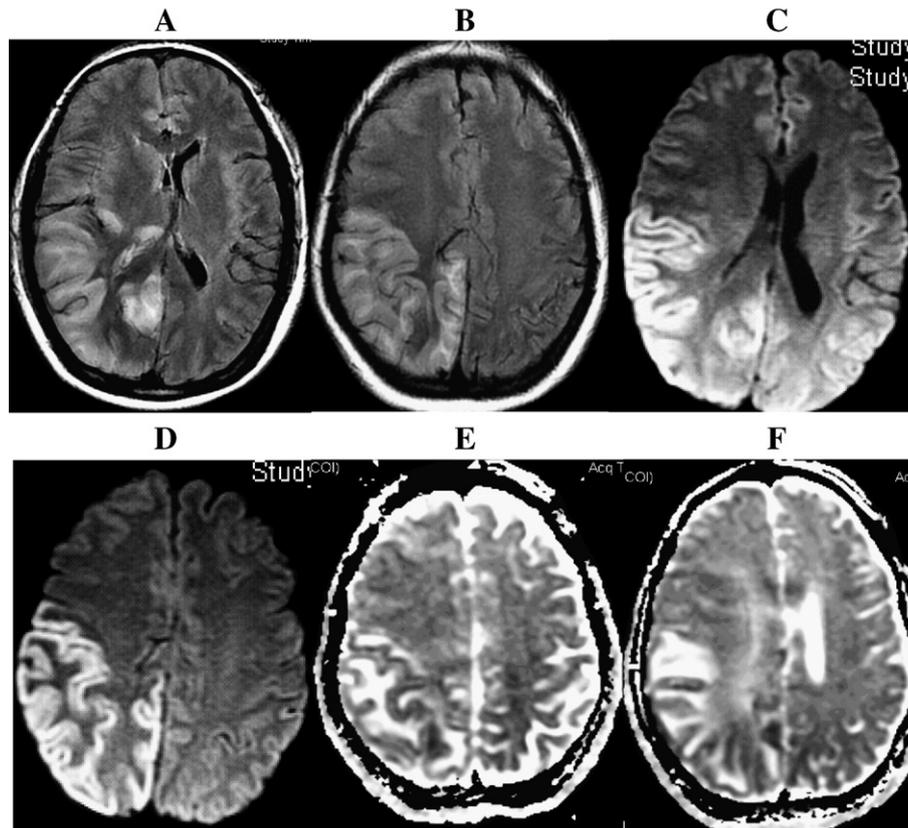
Brain MRI. A and B: Axial fluid attenuated inversion recovery (FLAIR) images show increased signal intensity and sulcal effacement involving a large portion of the right medial occipital and parietal temporal regions. C and D: The diffusion-weighted image obtained in this patient shows increased cortical signal (restricted diffusion) but decreased white matter signal (vasogenic edema). E and F: The corresponding apparent diffusion coefficient (ADC) maps confirm slightly decreased diffusion in the cortex (ischemia and cytotoxic edema) as compared to the contralateral side. The subcortical white matter has increased diffusion (non-restricted) consistent with vasogenic edema.
